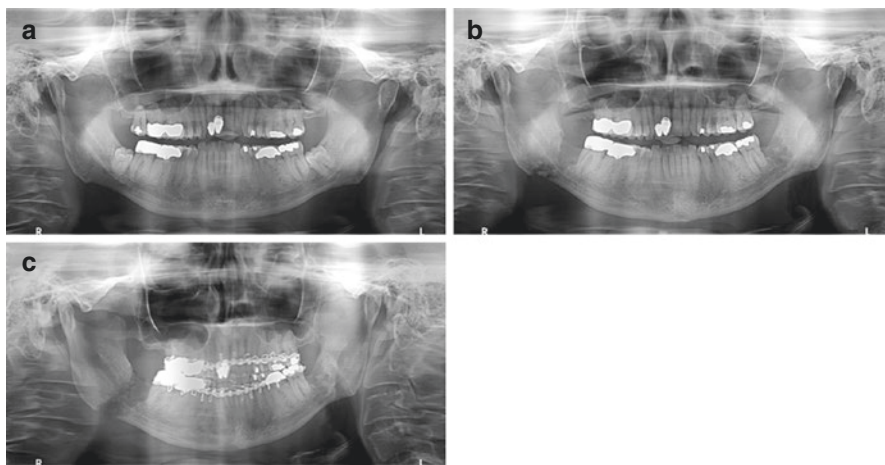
(a) Panoramic X-ray showing impacted mandibular third molars. (b) Panoramic X-ray reveals a nondisplaced fracture involving the right mandibular angle. (c) Panoramic X-ray after debridement, sequestrectomy and saucerization and placement of maxillo-mandibular fixation
